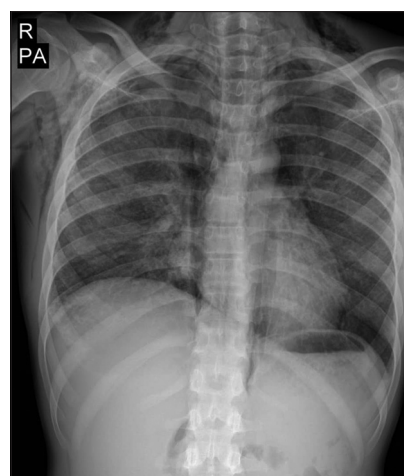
Chest X-ray after neck emphysema
